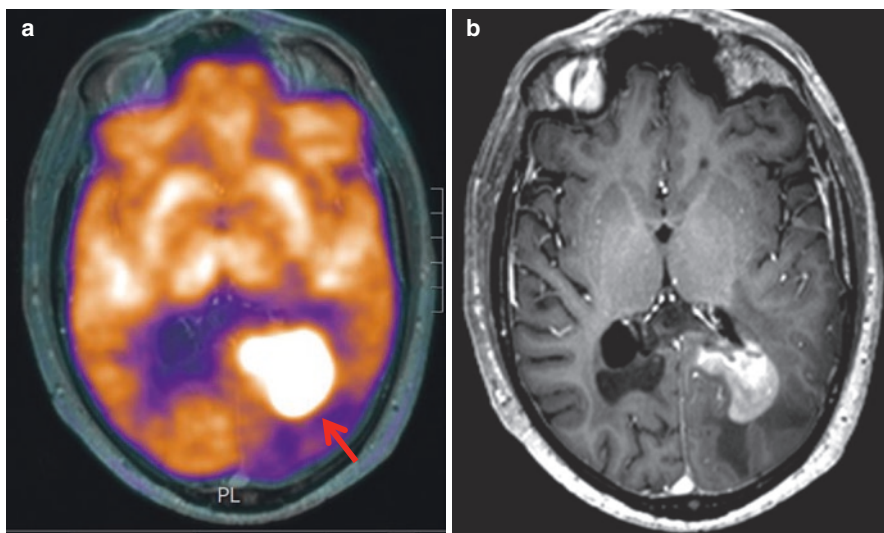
(a, b) Axial fused ^{18}F -FDG PET/MR (a) and post-contrast T1WI (b) demonstrate intense increased FDG uptake in the periventricular region of the posterior horn of the left lateral ventricle (a, arrow) which corresponds to an enhancing lesion on the post-contrast MR (b), in a patient with CNS lymphoma.
